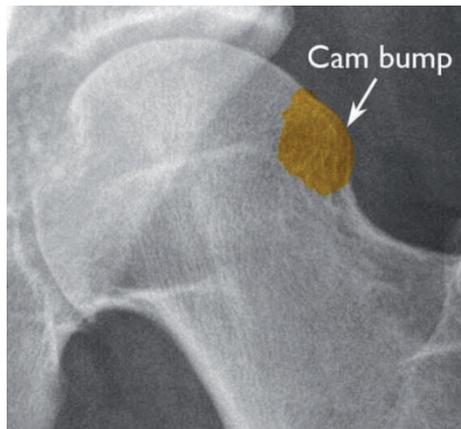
X-ray shows a CAM bump on the femoral head (Reproduced with permission: Diaz-Ledezma C, Higuera CA, Parvizi J: Mini-open approach for the treatment of FAI in Sierra RJ (ed); Femoroacetabular Impingement. Rosemont, IL. American Academy of Orthopaedic Surgeons, 2013. 81-91.)
